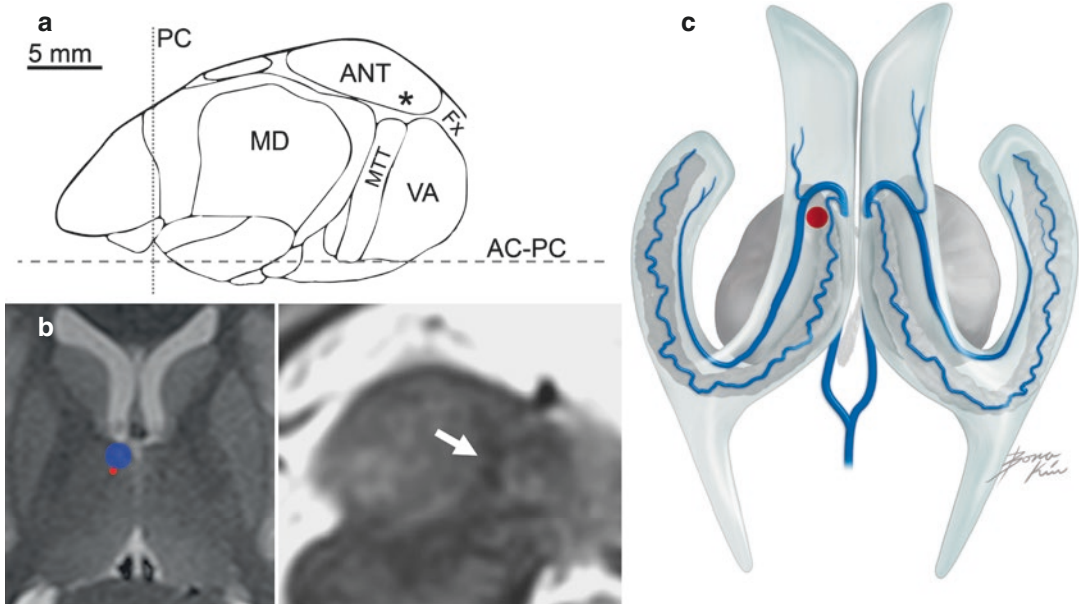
Targeting the ANT. (a) Sagittal section through the thalamus 8.2 mm lateral to the midline, adapted from [106]. The ANT lies on the superior surface of the thalamus. The surgical target (*) is slightly superior and anterior to the ANT-MTT junction. (b) Axial T2 (left) and sagittal STIR (right) MRI sections through the ANT. In the axial image, the right ANT and MTT are noted with blue and red circles, respectively. The MTT is visible on sagittal STIR images as a dark band (white arrow). (c)
